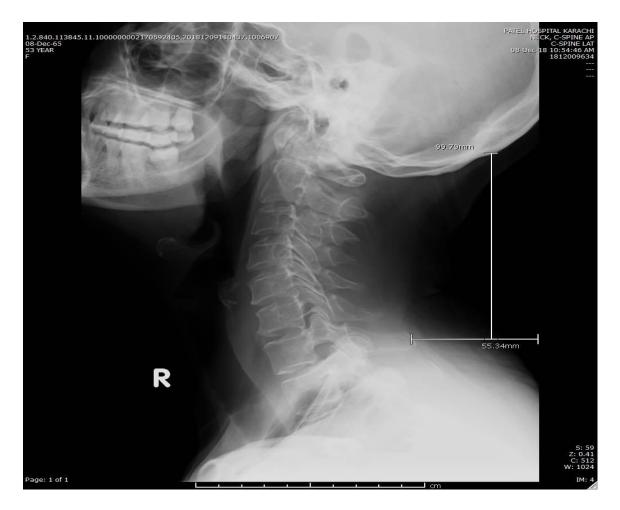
Radiograph of case showing Grade 2degenerative changes at Radiology Department, Patel Hospital, Karachi (2018-2019).
